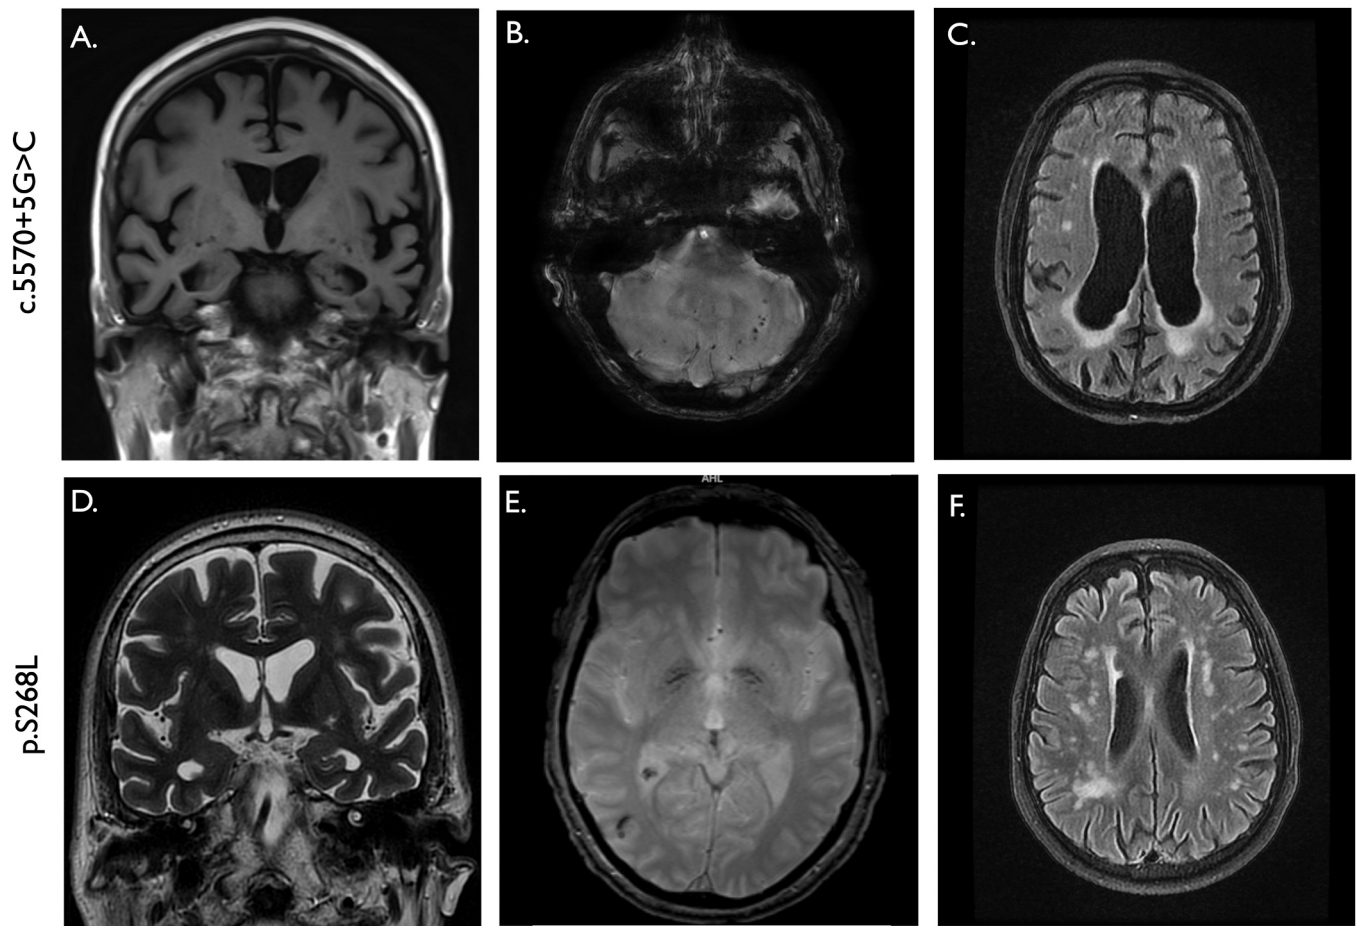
Neuroimaging in *ABCA7* PTC mutation PTC carrier P56 and missense carrier P60 with signs of CAA. P56 is carrier of the c.5570 +5G>C PTC mutation (images A–C), and P60 is carrier of the p.S268L mutation (images D–F). (A) Coronal MRI FLAIR image showing global cortical atrophy and pronounced bilateral hippocampal atrophy. There are a few periventricular T2 lesions compatible with chronic microvascular damage. (B) Axonal T2*-weighted MRI image where numerous cortico-subcortical MBs in both the occipital lobes are visible, presumably because of CAA. (C) Axonal MRI FLAIR image showing moderate chronic microvascular lesions in the deep white matter. (D) Coronal T2 weighted MRI image showing global cortical atrophy and bilateral hippocampal atrophy. (E) Axonal T2*-weighted MRI image where, linear susceptibility artefact in the right occipital lobe conferring to a small occipital ICH. (F) Axonal MRI FLAIR image showing moderate chronic microvascular lesions in the deep white matter. Abbreviations: FLAIR = Fluid attenuated inversion recovery.
